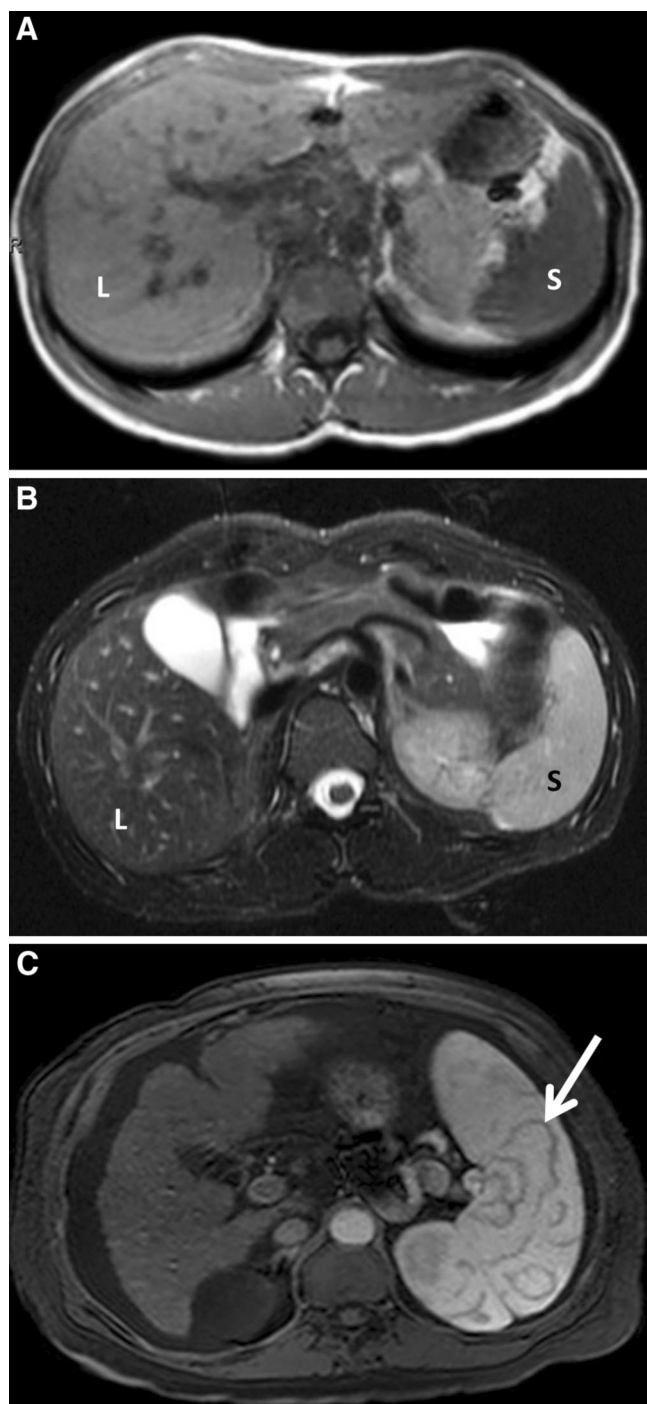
Normal MRI appearance of spleen. A and B axial T1- and T2-weighted gradient echo images respectively, show the spleen (S) is lower in signal than the liver (L) on the T1-weighted image (A) and higher in signal than the liver on the T2-weighted image (B). C Axial gadolinium-enhanced arterial phase T1-weighted image shows arciform pattern of enhancement of an enlarged spleen (*arrow*).
